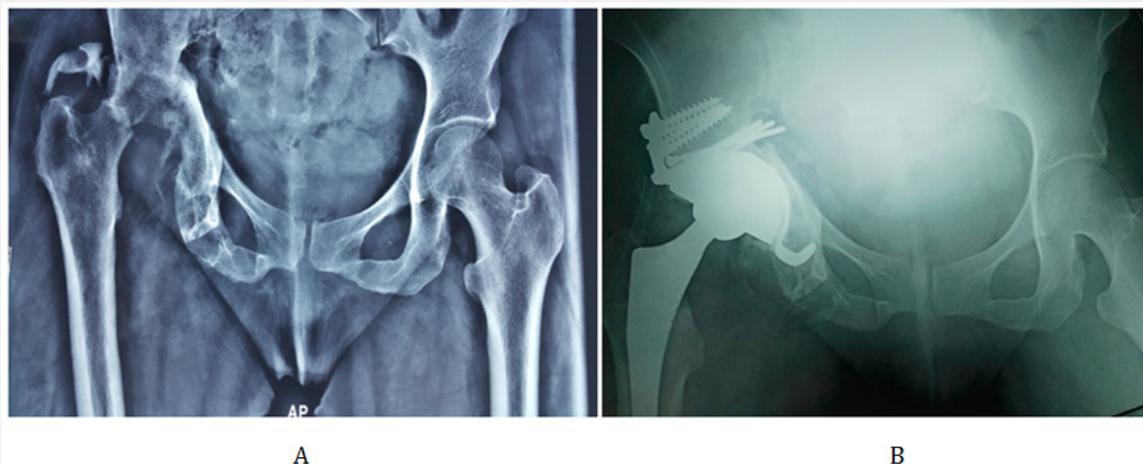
pre-operative x-ray of a 61 years old male patient with recurrent dislocation of bipolar prosthesis. B. post-operative x-ray of revision using cementless dual mobility cup with two pegs and screw (Serf comp).
